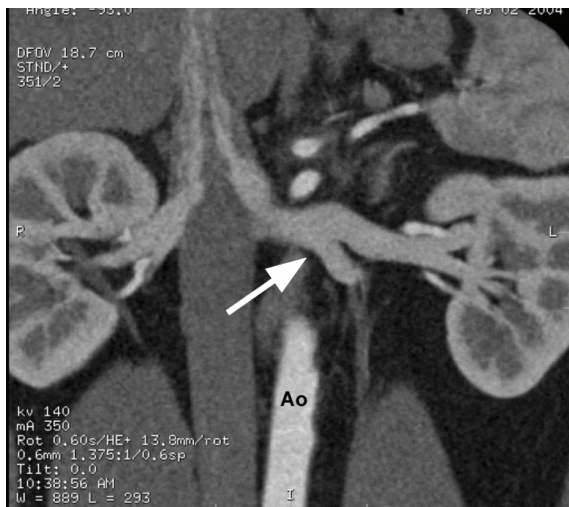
40-year-old male renal donor with late confluence of left renal vein. 3-D maximum-intensity-projection (MIP) CTA image demonstrates late confluence of left renal vein (white arrow). Notice left renal venous branches coalesce anterior to aorta (Ao)
